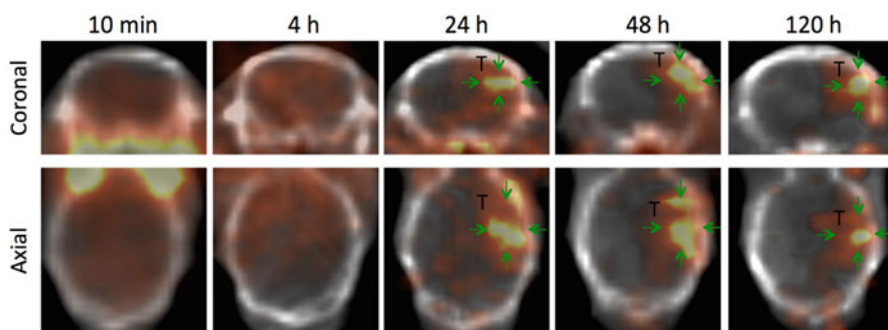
PET/CT imaging of brain tumor with ^{124}I -GNS nanoprobes. Top and bottom rows show coronal and axial image, respectively. (Adapted from Ref [36])
